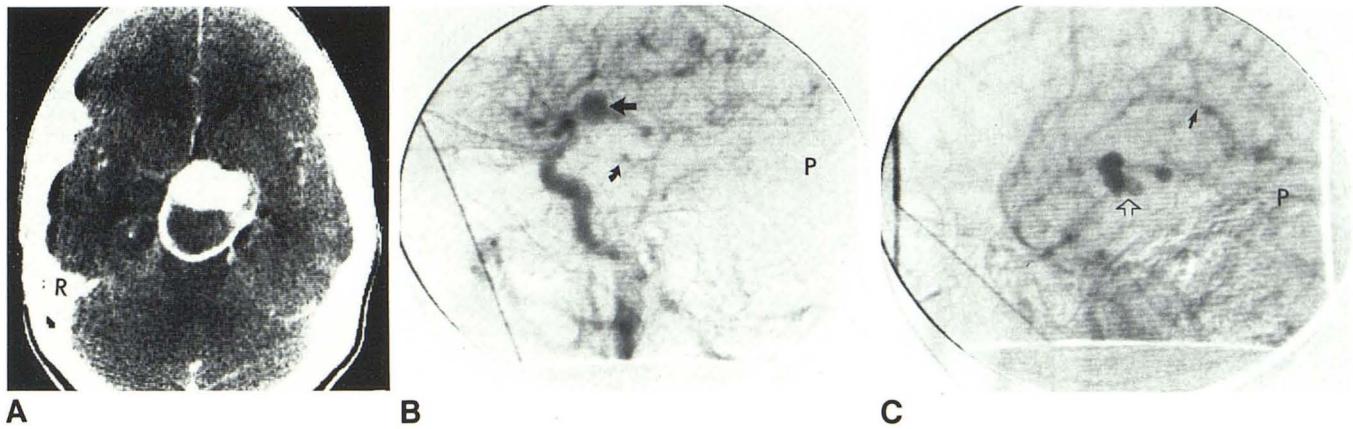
A, Axial CT. Large, partially enhancing suprasellar mass. R = right. B, Right lateral view. Arterial phase of IV digital subtraction angiogram showing aneurysm originating from proximal left posterior communicating artery (straight arrow). Right posterior communicating artery is inferiorly displaced due to mass
